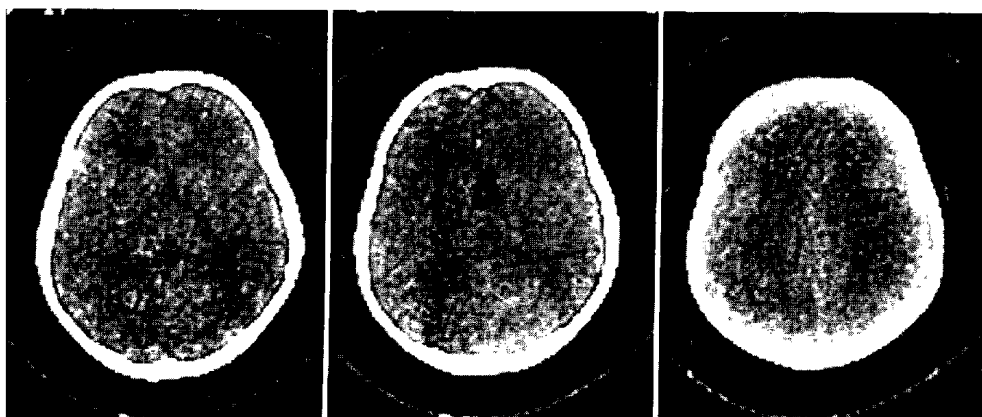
Cerebral contusion. 5-year-old boy. CT examined within 24 hours after trauma, demonstrates the so-called small ventricle pattern.
